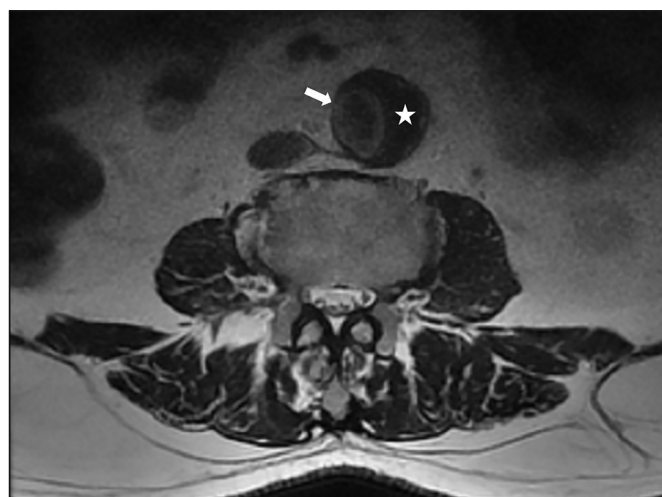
Abdominal aortic aneurysm (arrow) and mural thrombus (star) narrowing the lumen of the aorta in a crescent fashion in T2-weighted axial images in lumbar spinal MRI examination.
